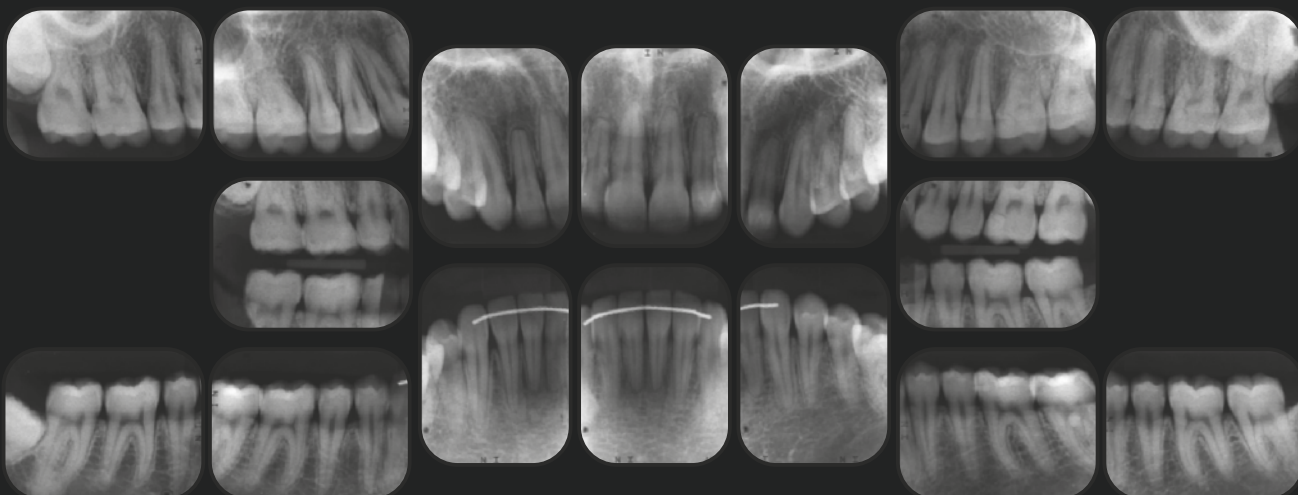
Sixteen-film periapical radiographs after laminate veneer placement.
